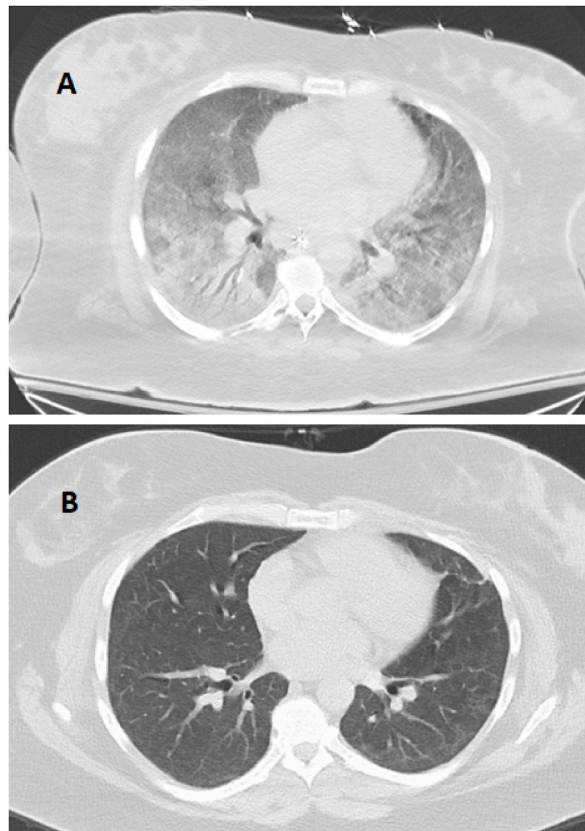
A. Chest CT before five-day course of IP (February 8, 2022). B. Chest CT one year after discharge from hospital (March 9, 2023).
